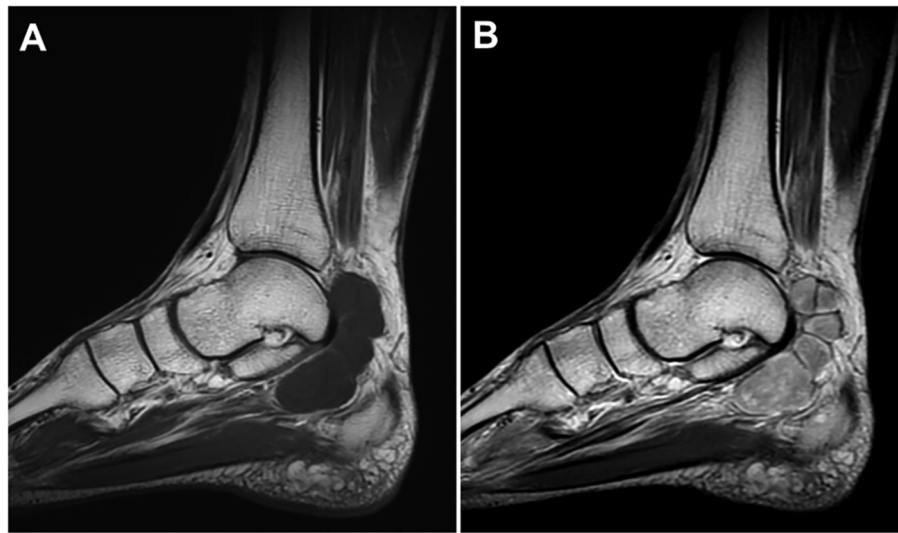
Sagittal magnetic resonance images of multinodular/plexiform schwannoma in the right ankle. The multinodular lesions reveal intermediate signal intensity on T1-weighted sequences (A) and heterogeneous high signal intensity on T2-weighted sequences (B).
